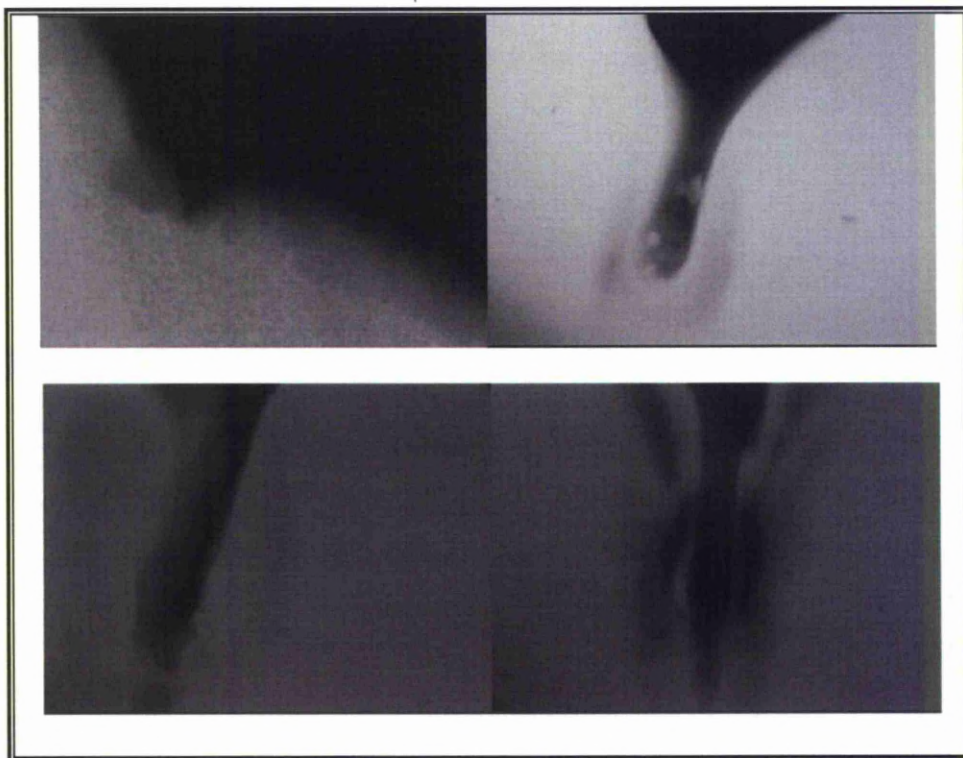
TMR radiographs.
